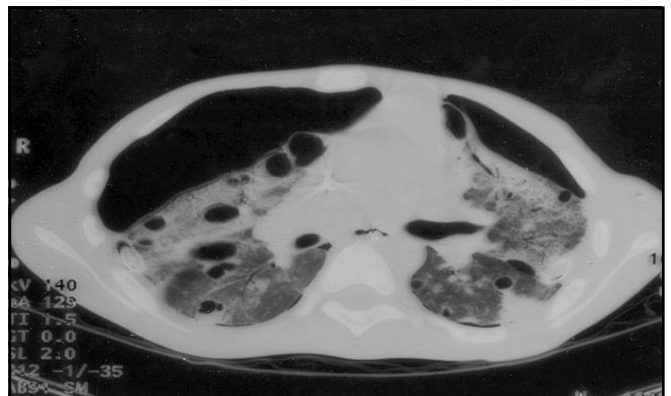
Computed tomography scan of the chest showing multiple pneumoceles and bilateral pneumothoraces.
